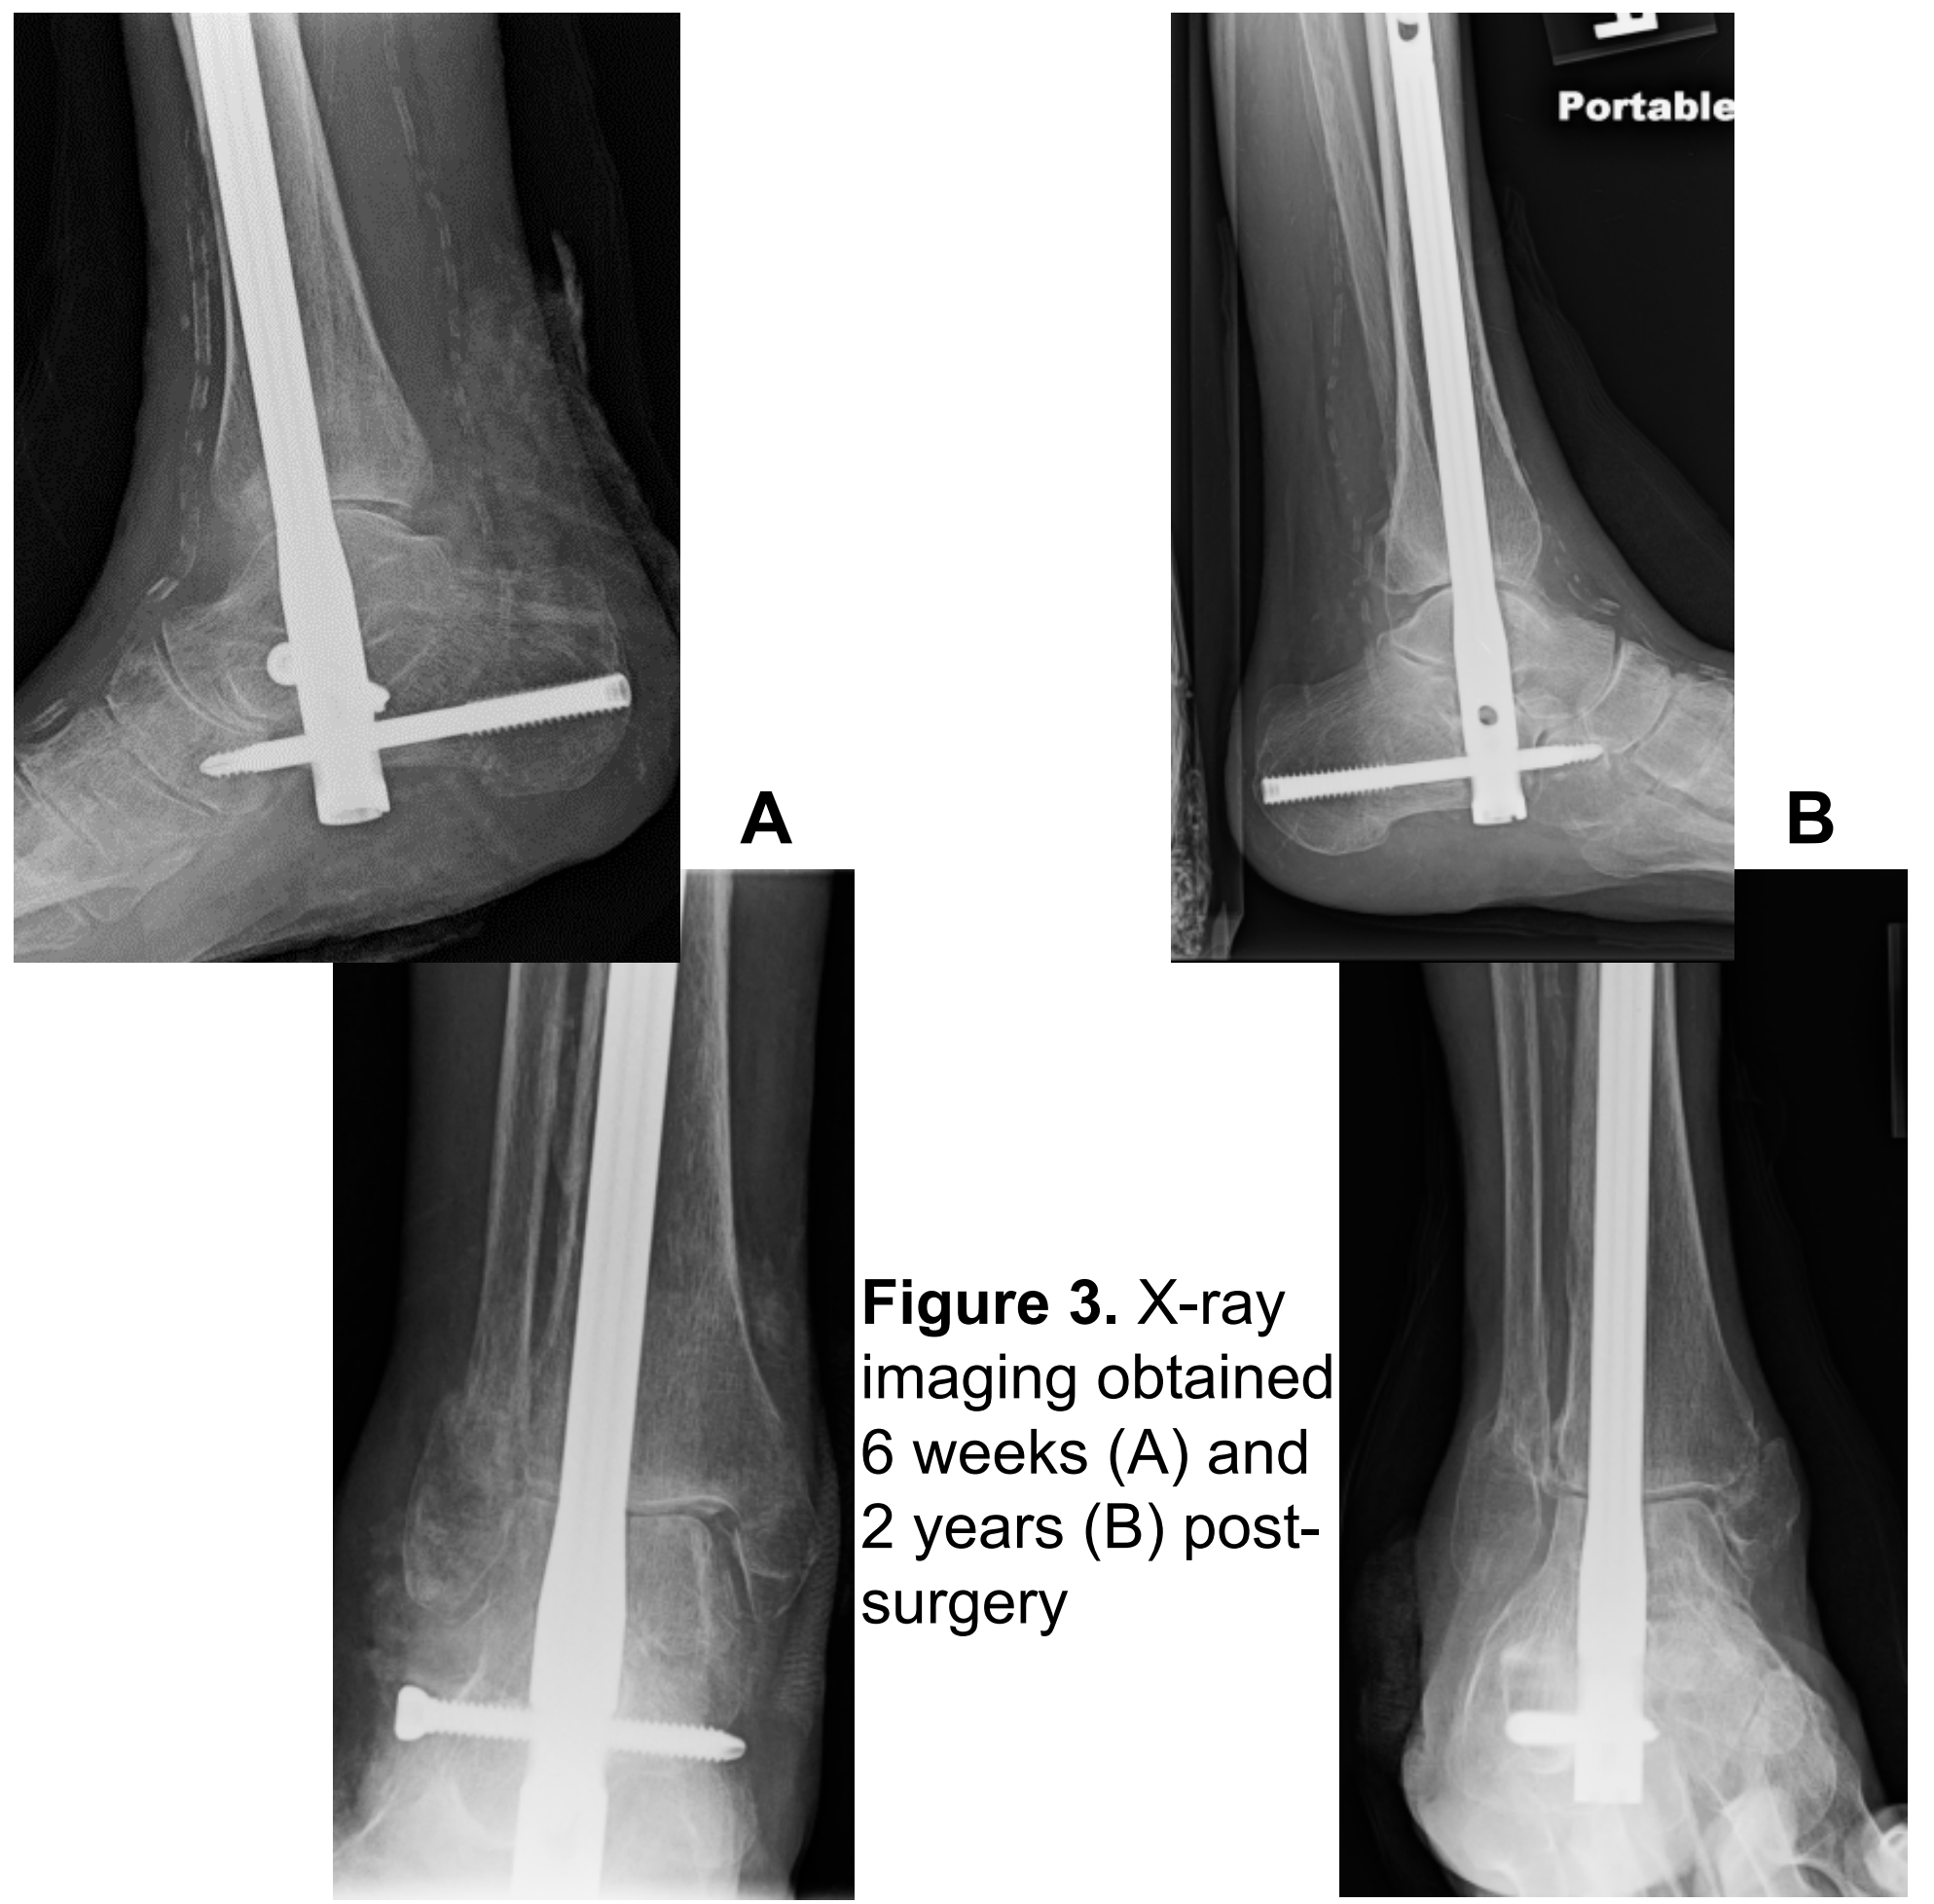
X-ray imaging obtained 6 weeks (A) and 2 years (B) post-surgery
